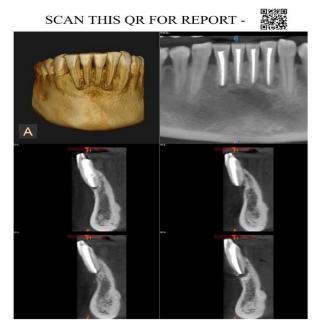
CBCT of the Patient with QR code to open the Report
